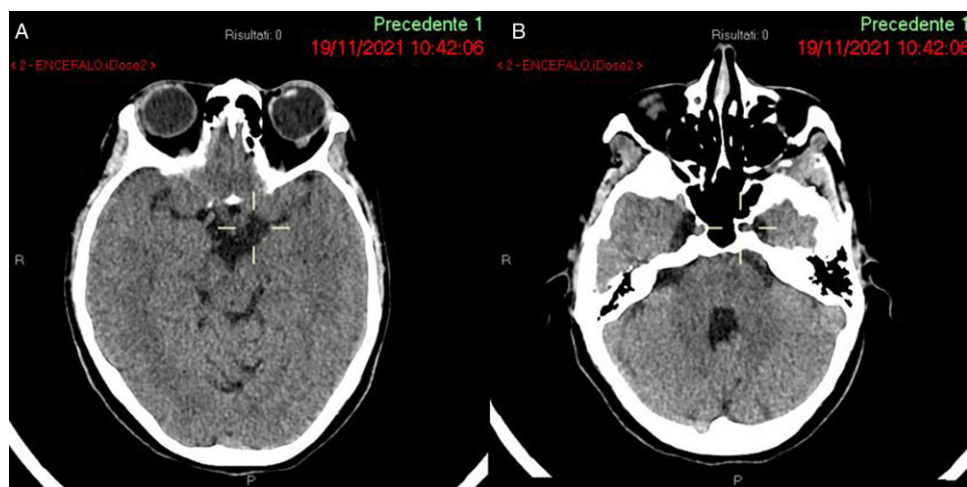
Patient's brain CT performed at the age of 38 years. Figure 1 a–b: Vermian dysmorphism with secondary fourth ventricle dysmorphism and enlargement of Meckel's cave.
